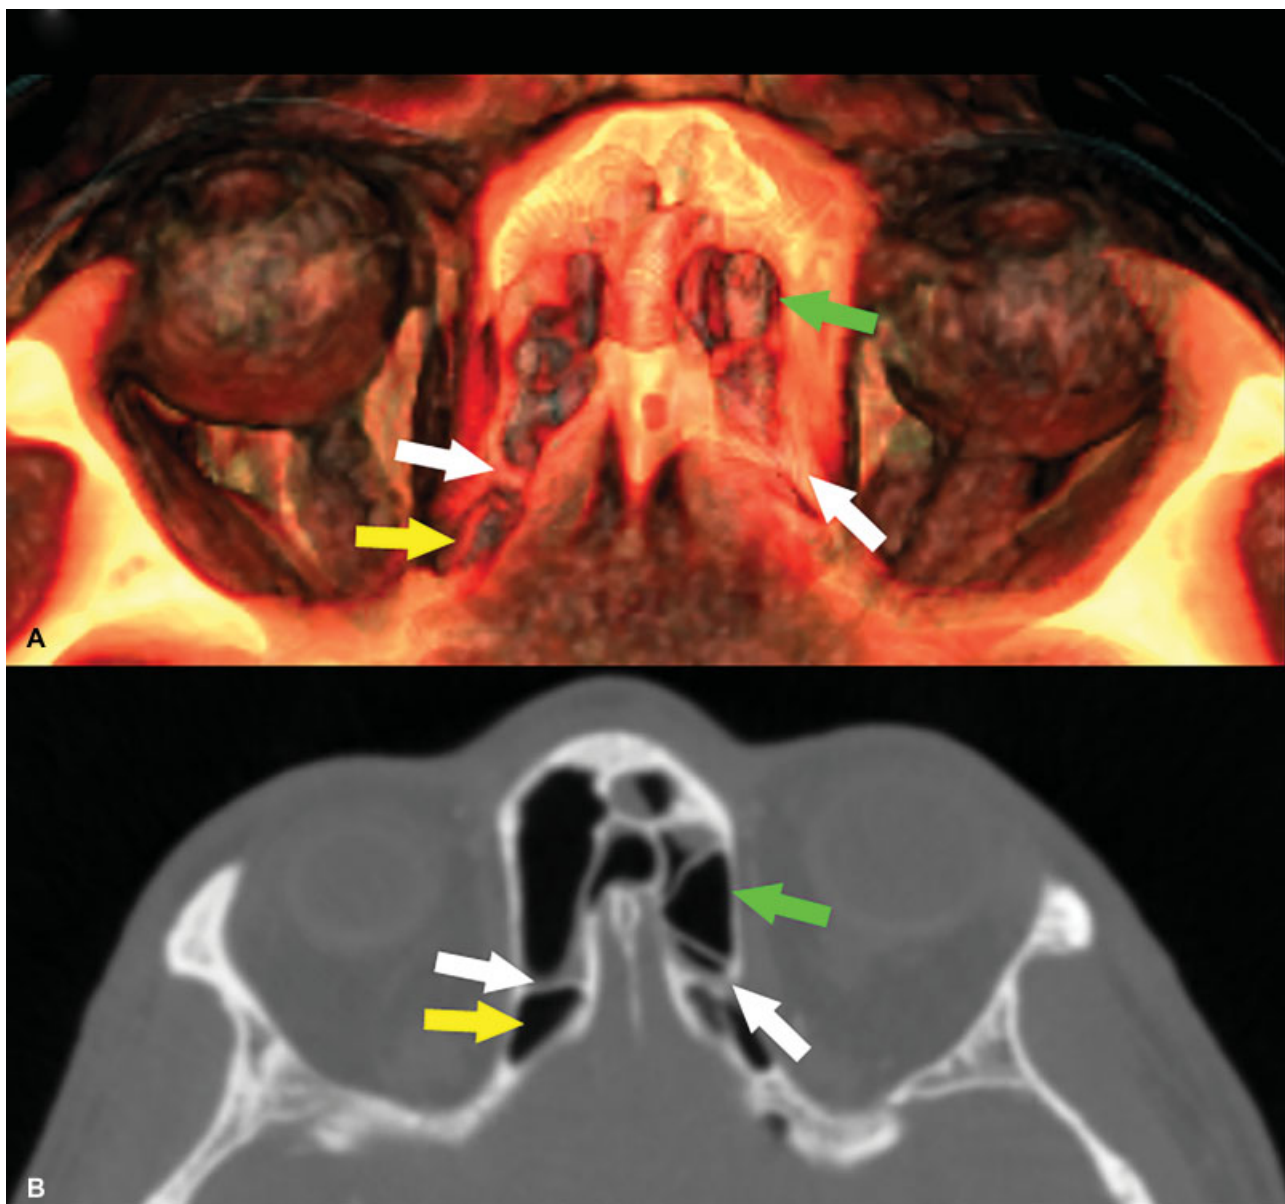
Comparison between the same image as obtained by means of 3D direct volume rendering (A) and computed tomography (B). In the axial plane, the anterior ethmoidal artery (white arrows), the frontal sinuses (green arrows), and the supraorbital recesses (yellow arrows) are visible.
